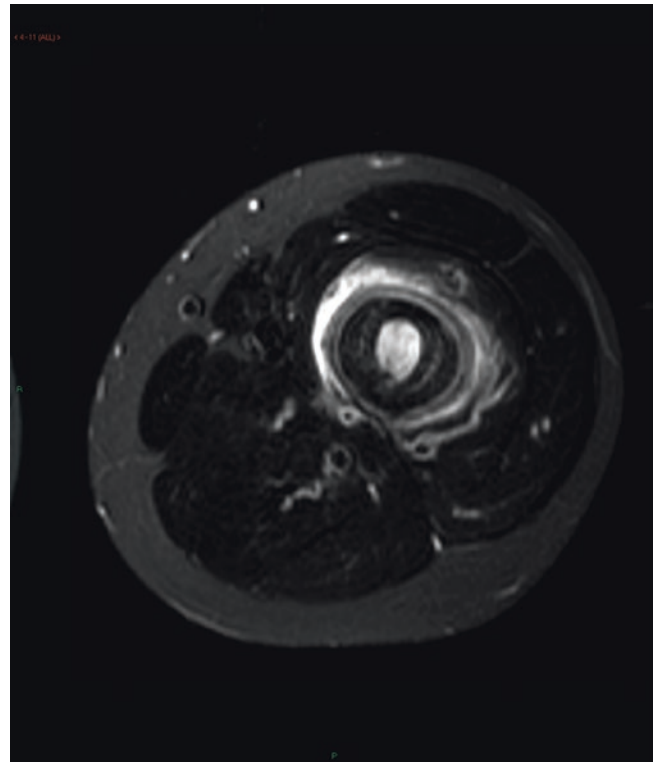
Axial T2W MRI in Ewing's sarcoma. There is circumferential periosteal reaction of the femoral diaphysis with surrounding soft tissue oedema
